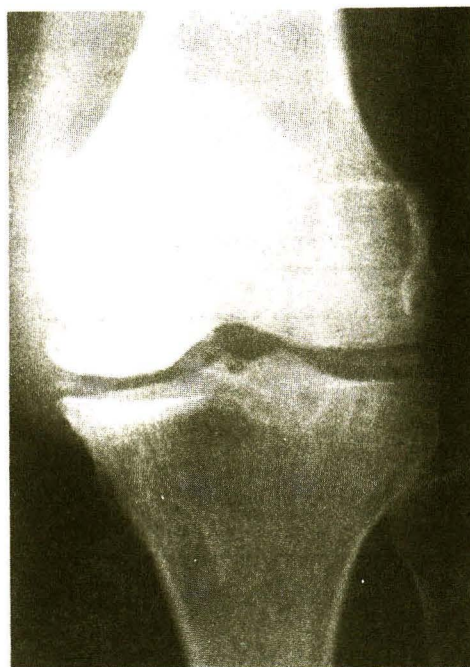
Radiograph of the knee showing calcific density in both menisci which is typical of chondrocalcinosis.
